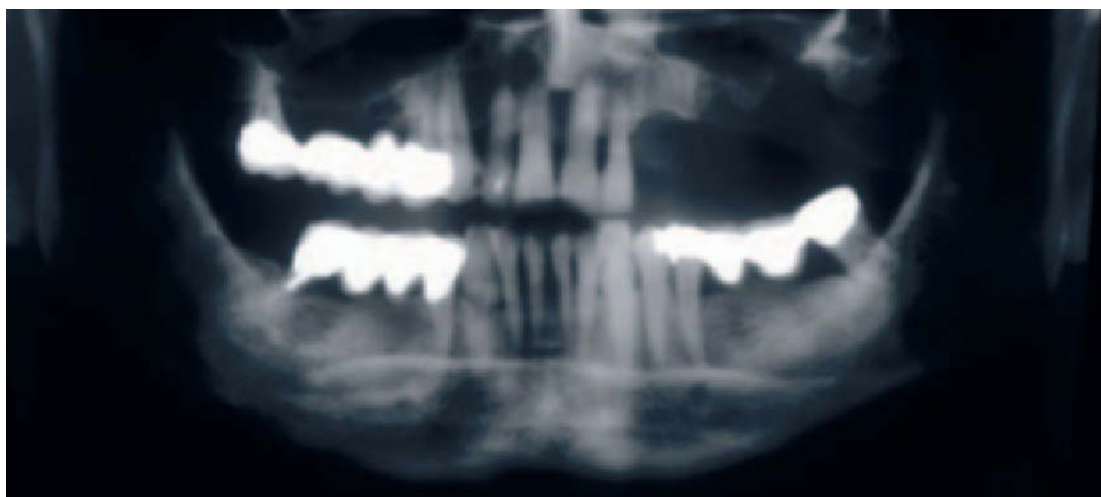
Panoramic X-ray shows inadequate bone volume beneath sinus on the left side.
